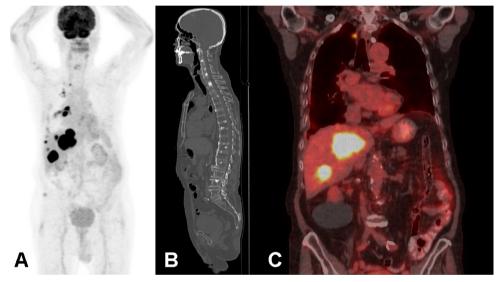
Positron emission tomography-computed tomography (PET-CT) in an 85-year-old man with rectal cancer and a history of anterior rectal resection. A, C) Coronal maximum-intensity-projection (MIP) and fused PET-CT images showing liver lesions with intensive FDG uptake (SUVmax 8.2) suggestive of the primary tumor metastatic disease and multiple FDG non-avid bone lesions. B) Sagittal CT images reveal sclerotic bone lesions highly suspicious for metastasis from prostate cancer. A prostate biopsy confirms the diagnosis.
